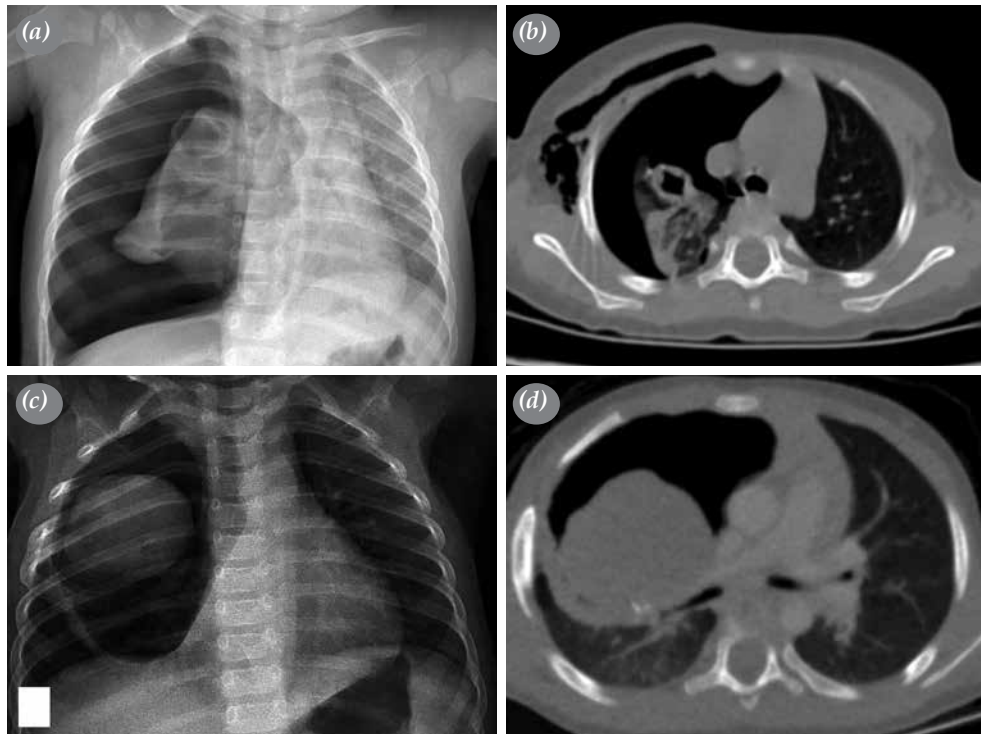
(a) First application with pneumothorax. (b) Cavitory lesion on right upper lobe. (c) Second application, an opacity seen in right superior lobe on chest X-ray. (d) a 5x7-cm lesion (Case 2).
